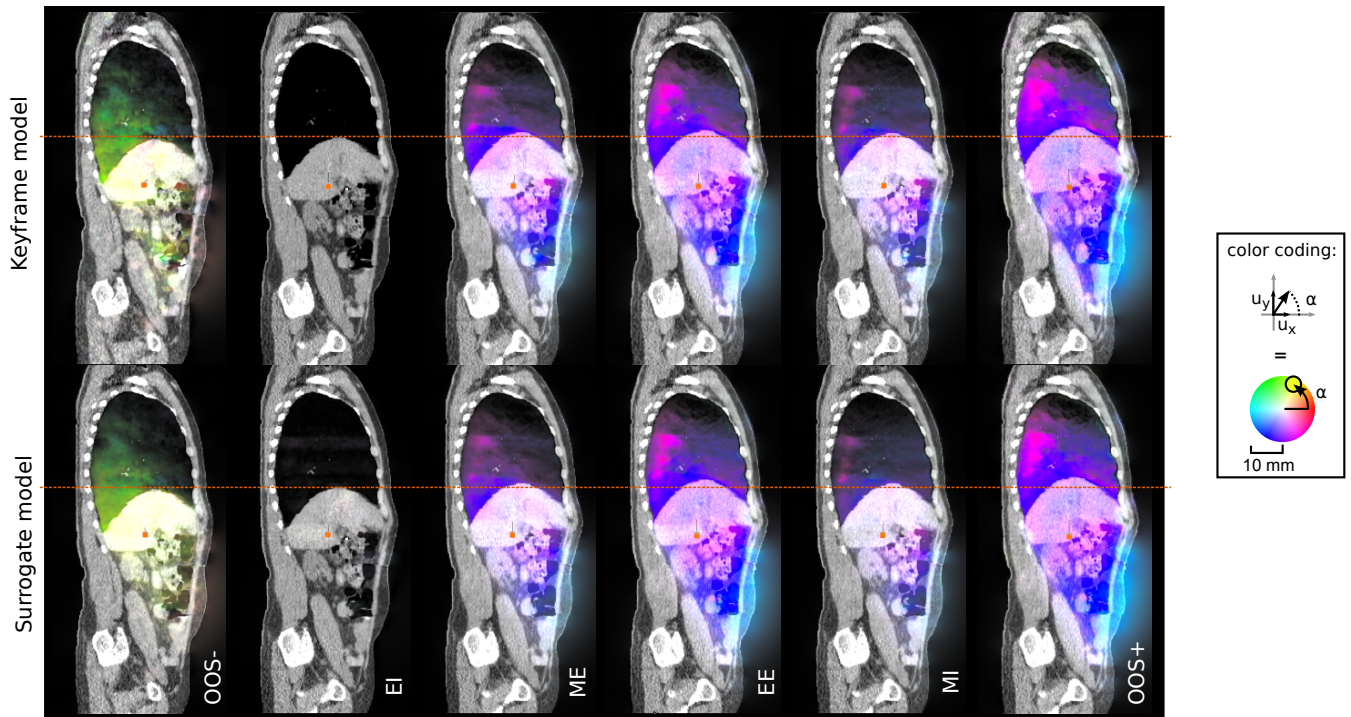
Resampled sagittal slices of the virtual patient CT data during the breathing sequence EI->ME->EE->MI and out-of-sample (OOS) predictions for both the key frame and the surrogate model. The direction of the displacements projected onto the slice are color code by the HSV color wheel, amplitude is indicated by opacity of the overlay (total opaqueness corresponds to 10 mm).
